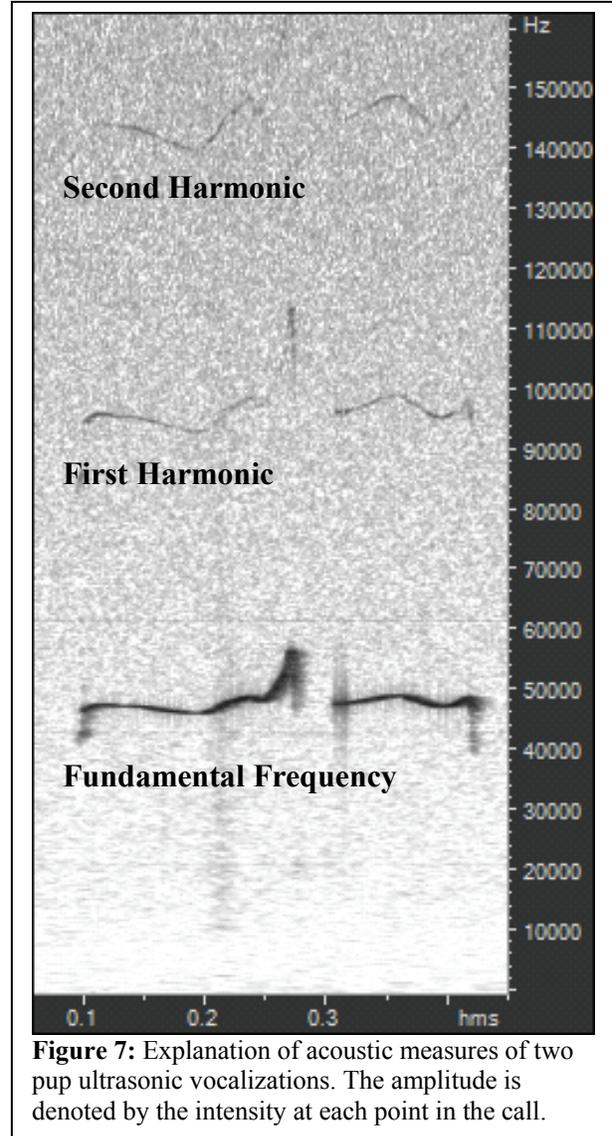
Explanation of acoustic measures of two pup ultrasonic vocalizations. The amplitude is denoted by the intensity at each point in the call.
